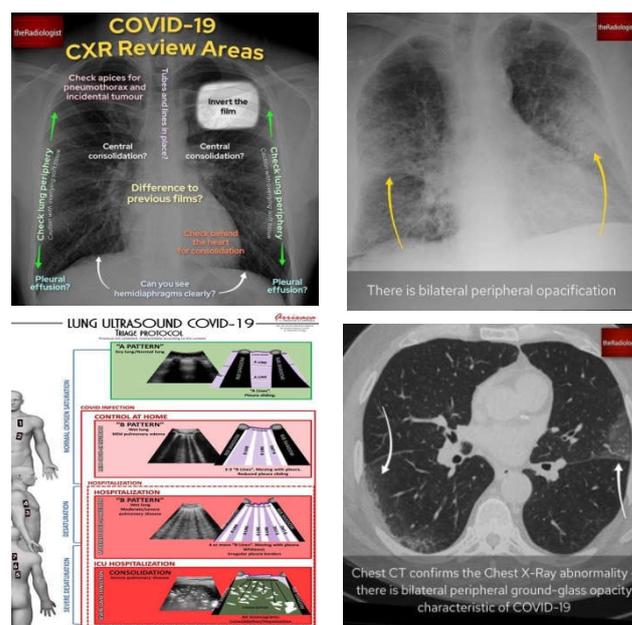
Chest X ray, lung ultrasound and CT scan showing diagnostic features of COVID-19
